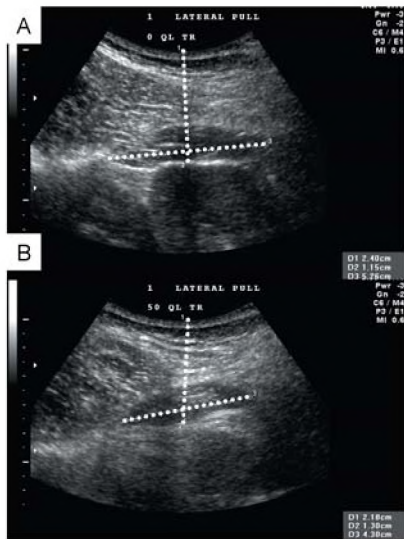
B-mode ultrasound image of quadratus lumborum (right side) relaxed (A) and during exertion of 50% of maximal right lateral flexion force (B). Both images show the distance from the muscle to the skin (D1) A-P thickness (D2) and M-L thickness (D3).
